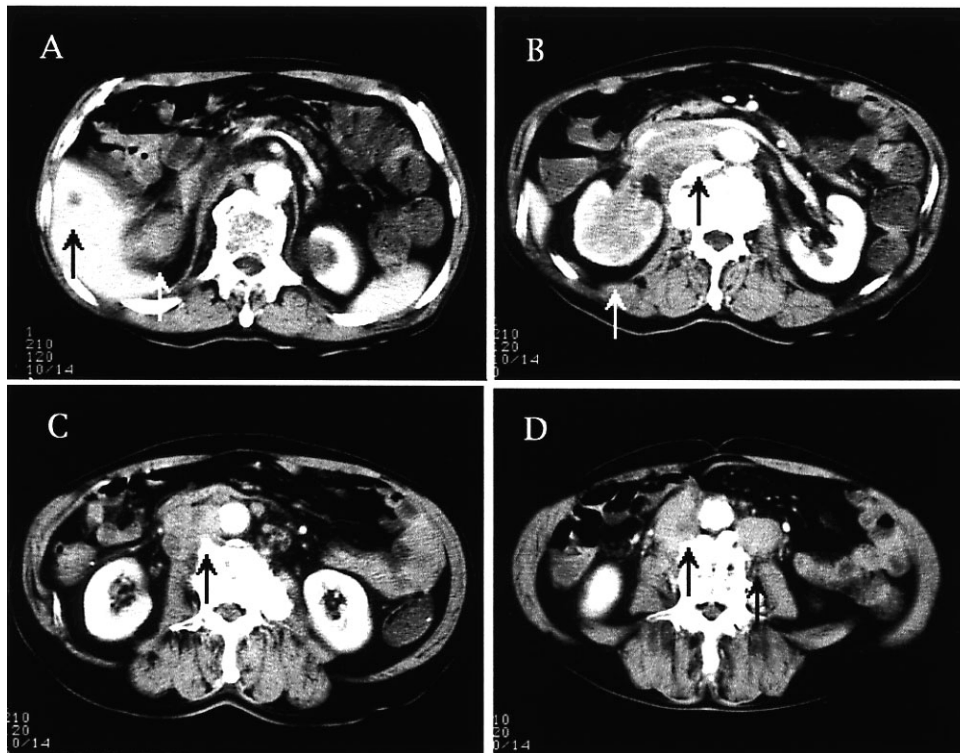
Enhanced CT revealed a hypo-enhanced right pelvic tumor extending to the renal cortex (*white arrows* in A and B) with liver metastasis (*black arrow* in A) and paraaortic lymph node metastases (*black arrows* in B, C, and D).
